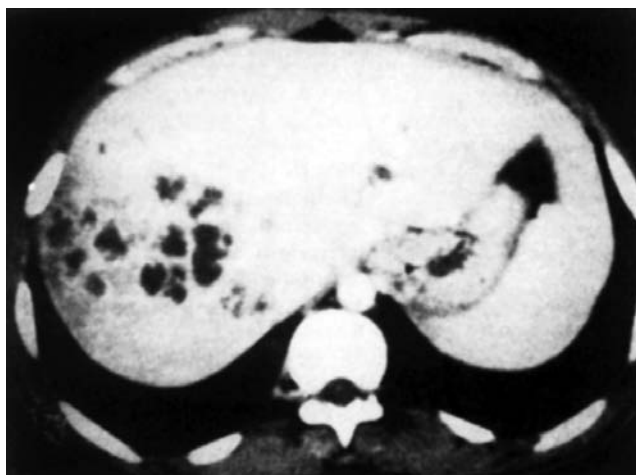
Liver abscess. CT scan (contrast enhanced) showing multiple coalescent hypodense areas (right lobe of liver) consistent with pyogenic liver abscesses.
